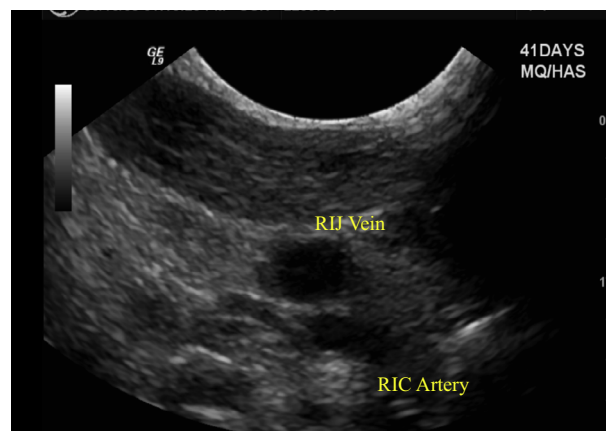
Ultrasound picture showing short axis view for the neck vessels resolution of the thrombosis of the right internal jugular vein after r-TPA. RIJ: Right internal jugular, RIC: right internal carotid.
